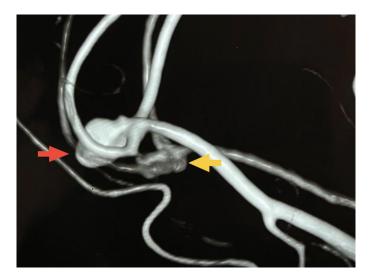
Three-dimensional reconstruction of cerebral CT angiography showing a saccular aneurysm of the left pericallosal artery measuring approximately 6 mm (red arrow), with a wide neck, located in the A3 segment of the ACA, projecting superiorly and medially, adjacent to the rostrum of the corpus callosum. Note the tortuous trajectory of the intracranial vessels and the emergence of the contralateral pericallosal branch, partially obscured by vascular overlap. The image supports the diagnosis of a Type 1 mirror aneurysm, with both aneurysms originating from the same vessel, the right one measuring approximately 3 mm (yellow arrow).
